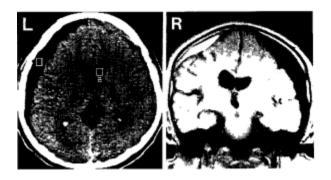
displays a CT scan (on the left) and a T1-weighted MR image (on the right) taken 98 days after the injury. It shows fluid buildup without an increase in volume on the left side, and the appearance of a thin layer of blood between the brain and its outer covering (subdural hematoma) on the right side.
